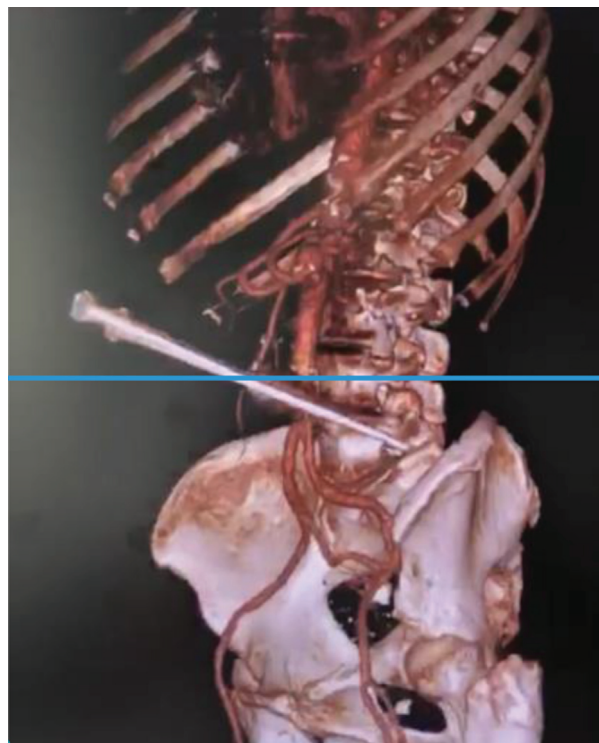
Reconstruction from multidetector contrast enhanced computed tomography angiography (CTA) showing penetrating injuries to the stomach, the third (inferior/horizontal) part of the duodenum, the L4-5 left vertebrae, and the infrarenal abdominal aorta.
